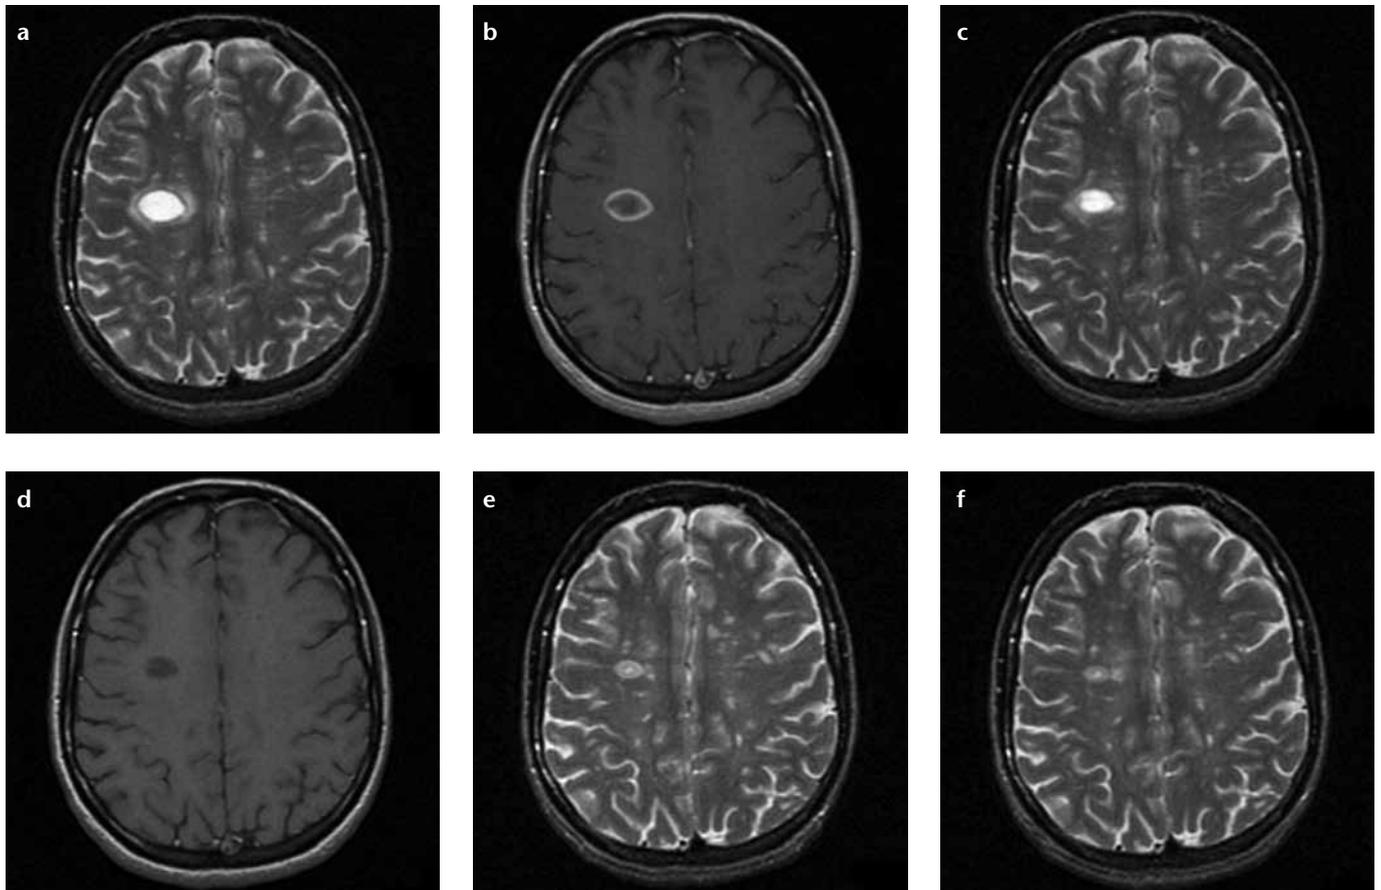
a–f. An axial T2-weighted image (a) with an ovoid Type II lesion in the right corona radiata associated with other Type III punctate shows less hyperintense lesions in the white matter. The postgadolinium axial T1-weighted image (b) has a fairly regular rim of contrast enhancement around the periphery of the right-sided Type II lesion. After three weeks, the T2 aspect persisted (c), even when the contrast enhancement had disappeared (d). As the lesions decreased in size and core intensity, a progressive decrease and shift of the hypointense rim toward the lesion center was observed three (e) and nine (f) months later, respectively.
